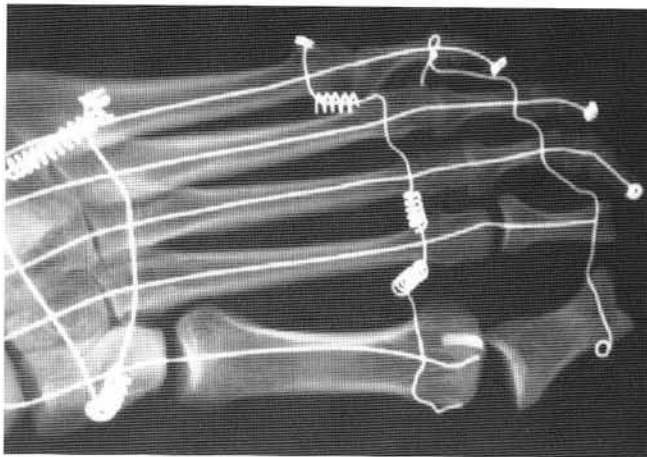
An AP radiograph of the foot in figure one demonstrating the apparent lateral position of the cristae relative to the first metatarsal bisection.
